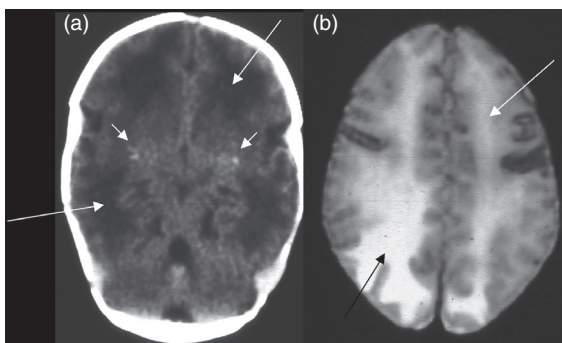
Congenital rubella on (a) CT and (b) T2 MRI, including calcifications (short arrows) and leukoencephalitis (long arrows) with white-matter low densities and T2 high intensities.
